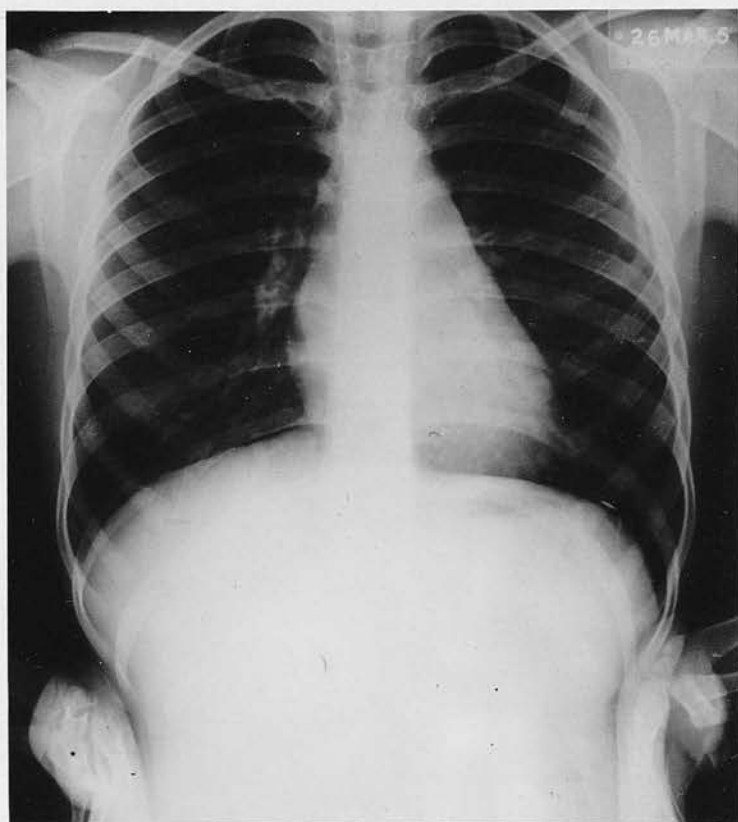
Radiograph of Case 51. Persistence of Left Atrial enlargement lyr. after ligation of Patent Ductus Arteriosus.
